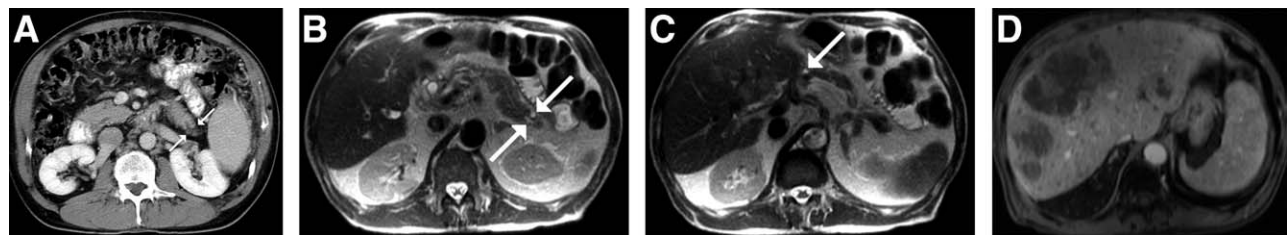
A 60-year-old male patient who received OLT due to HCV cirrhosis and HCC. Nine years after OLT, this patient presented with multiple liver metastasis from MANEC. (A) Pre-LT, venous phase axial CT image shows tiny small pancreatic cysts in the tail of the pancreas (arrows). (B) Axial T₂-weighted MRI 9 years after LT shows stability of the cysts in the pancreatic tail (arrows). (C) T₂-weighted MRI 9 years after LT showing a newly developed 0.6 cm cyst at genu of the pancreas (arrow). Biopsy revealed diagnosis of MANEC. (D) T₁-weighted MRI post-gadolinium at the portovenous phase shows multiple liver metastasis. Biopsy revealed neuroendocrine tumor liver metastasis.
